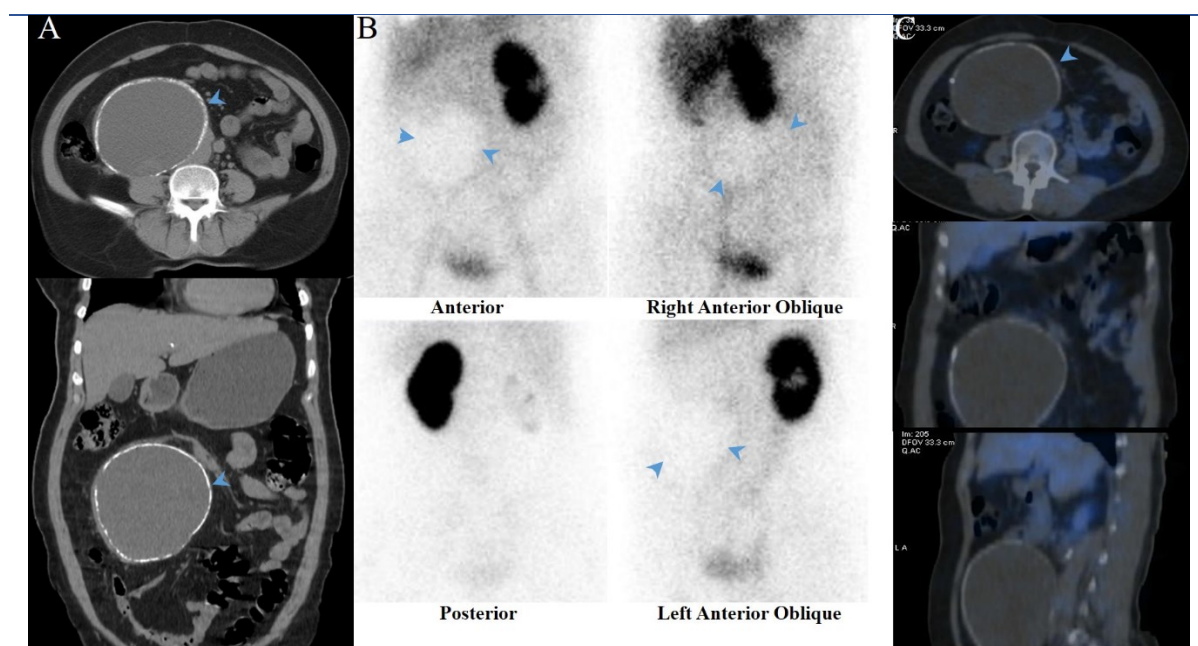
(A) The non-contrast-enhanced CT scan shows an enlarged mesenteric hydatid cyst (arrowheads) exerting compressive effects on the right ureter. (B) The [^{99m}Tc] Tc-DMSA scan reveals a significant photopenic area in the mid-abdomen (arrowheads). Subsequent SPECT/CT imaging (C) confines the photopenic area to the large mesenteric hydatid cyst with a surrounding rim of calcification
